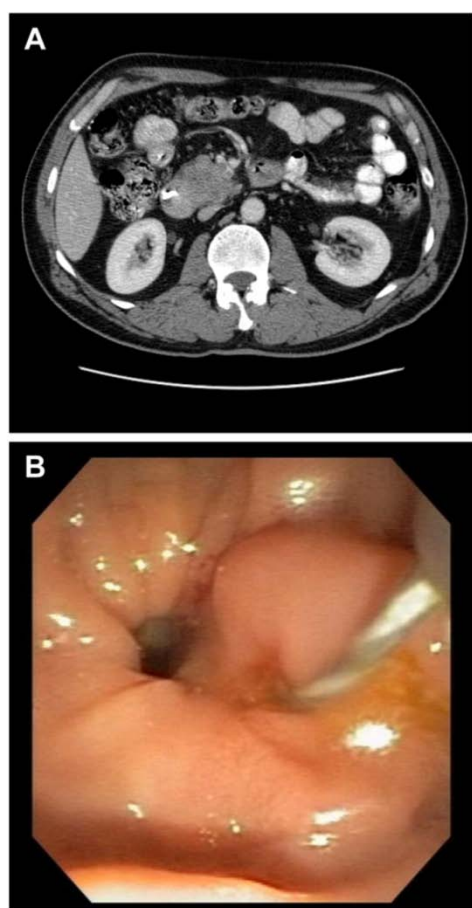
A. Computed tomographic (CT) scan showed a large mass in the pancreatic head extending into the uncinate process and involving the superior mesenteric vein (SMV) with peripancreatic lymphadenopathy. B. Endoscopic picture of the mass at the ampulla of Vater.
